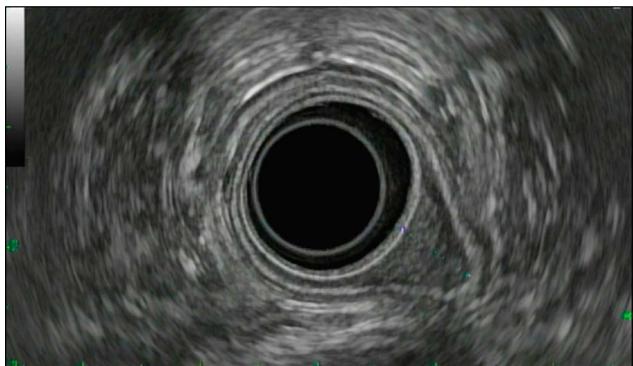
Endosonographic examination revealed the tumor confined to the first 2 mucosal layers with an intact submucosal layer consistent with T1a adenocarcinoma.
